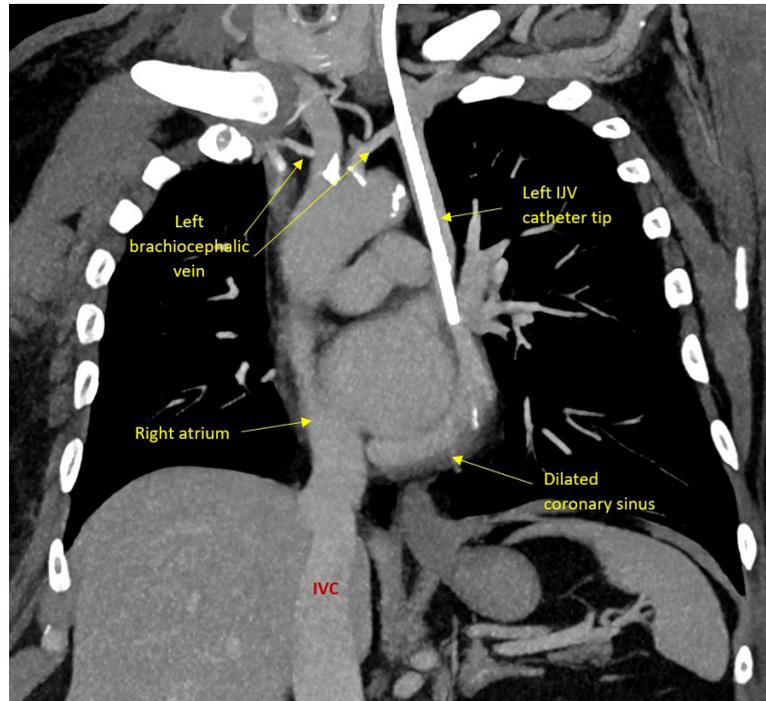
An axial slice of the performed computed tomography venogram demonstrating continuation of the coronary sinus draining into the right atrium.
